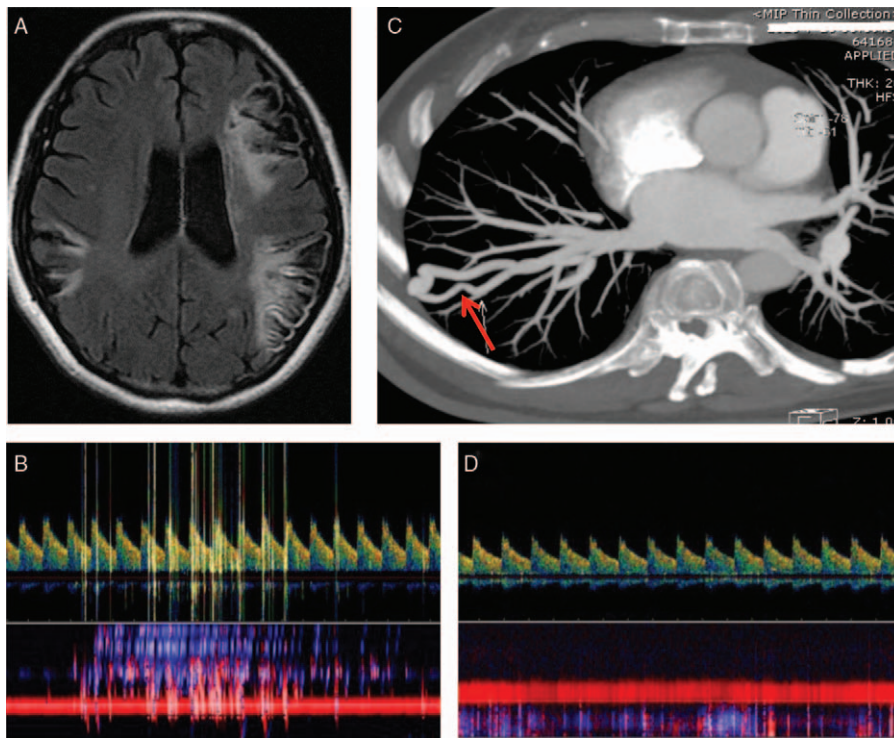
Patient's neuroimaging of particular diagnostic values. (A) Fluid-attenuated inversion recovery sequence in 2011 demonstrating multiple territory infarcts, involving bilateral middle cerebral arteries. (B) Contrast transcranial Doppler ultrasound (TCD) detecting a typical "curtain" appearance of microbubbles, indicating a right-to-left shunt. (C) CT pulmonary angiogram demonstrating a moderate-sized pulmonary arteriovenous malformation (PAVM) in the right lower lobe (arrow). (D) Post-treatment contrast TCD study demonstrating complete resolution of previous microbubble signals. PAVM=pulmonary arteriovenous malformation, TCD=contrast transcranial Doppler.
